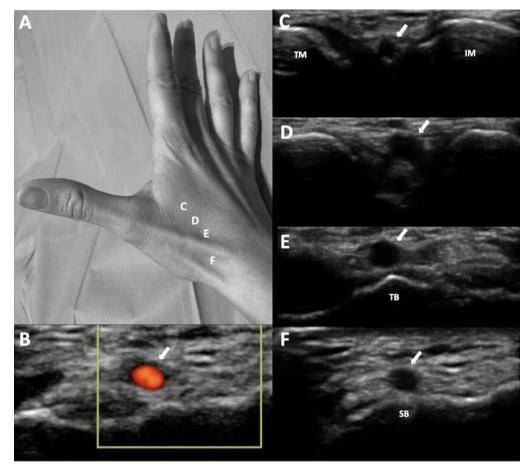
A: markers for ultrasound positioning in the anatomical snuffbox. B: patency of the distal radial artery (DRart) confirmed by color Doppler ultrasound. C-D: course of DRart between the metacarpal bones. E-F: recommended puncture sites of the DRart on a surface bone. IM, index metacarpal; SB, scaphoid bone; TB, trapezium bone; TM, thumb metacarpal.
